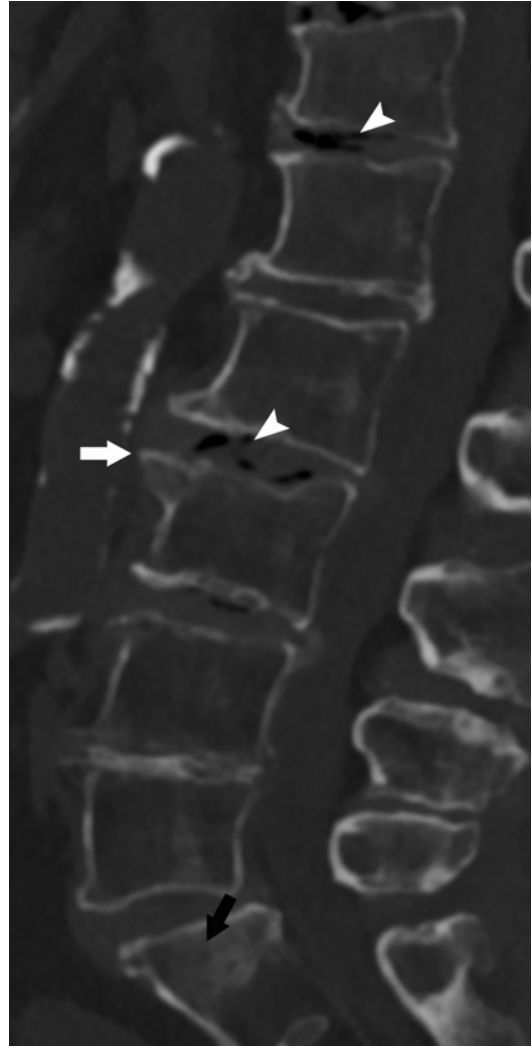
Multilevel degenerative disk disease. CT sagittal reformat shows multiple disk space narrowing with intradiscal gas (*arrowheads*) and osteophytes (*arrow*)
